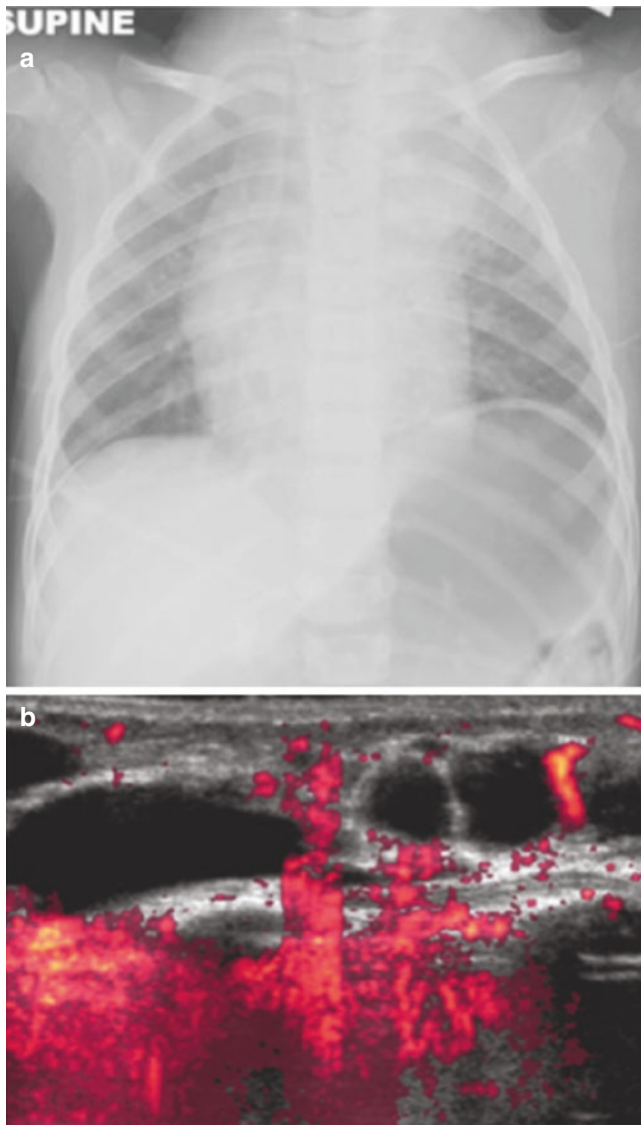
2-year-old boy who presented with shortness of breath. (a) Frontal chest radiograph shows a fullness of the left aspect of the neck with a soft tissue mass in the left upper mediastinum with left apical pleural thickening. The constellation of findings is suggestive of a lymphatic malformation. (b) Ultrasound of the neck mass reveals a multicystic mass with no flow within the cysts, consistent with the suspected lymphatic malformation
